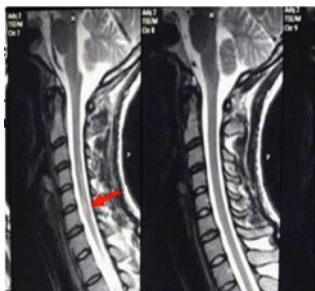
Sagittal cervical MRI. T2. Red arrow: typical MS myelitis.
